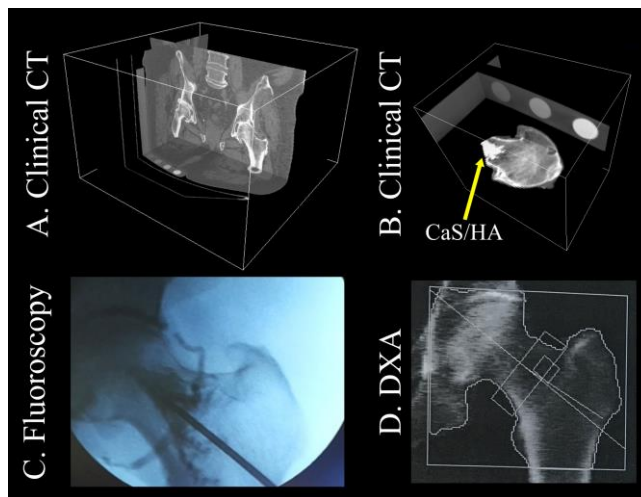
Samples and images acquired for study IV. A) Clinical CT scans before surgery were used to create FE models of the proximal femur. B) Clinical CT scan of a femoral head after resection used to identify the region where CaS/HA spread. C) Fluoroscopy was used during CaS/HA injection to follow the spreading. D) DXA scans of the patients with fragility hip fractures to confirm that they were osteoporotic.
